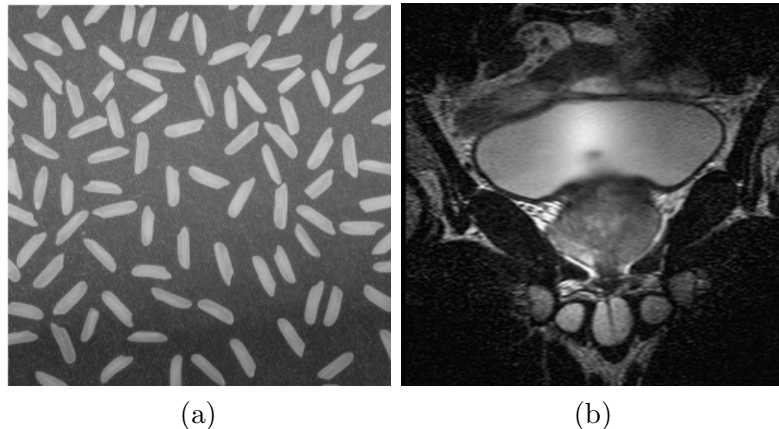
(a) Grey-Scale Image showing a cluster of bacteria present in a fluid having non-uniform texture, darker at the bottom and brighter on the top and center portions. (b) MRI of the pelvis with a slowly varying background variation.
